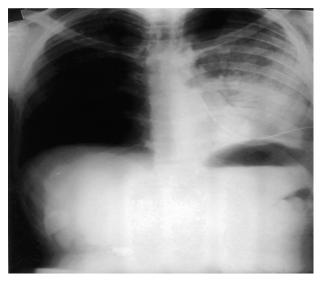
Chest radiograph (postero-anterior view) showing fully expanded lung with ill-defined opacity in the middle and the lower zones with intercostal drain *in situ*.
